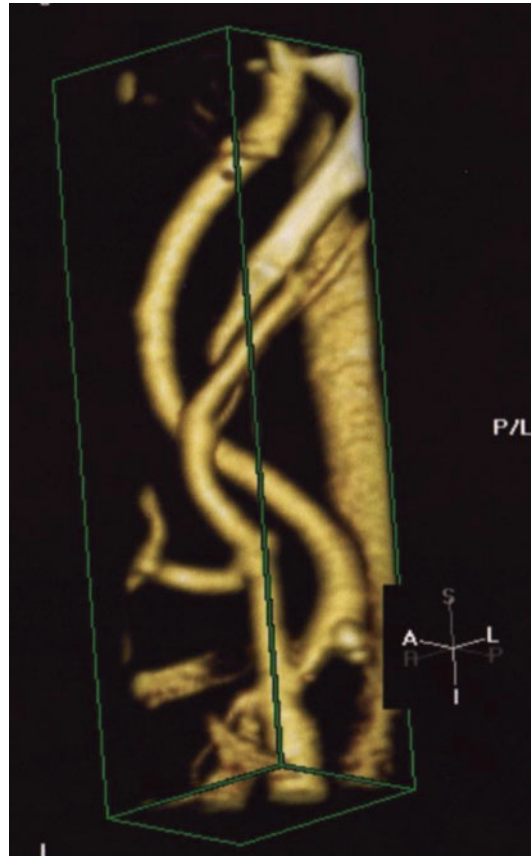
CT angio can depict carotid stenosis in relation other nearby structures, such as the styloid process
